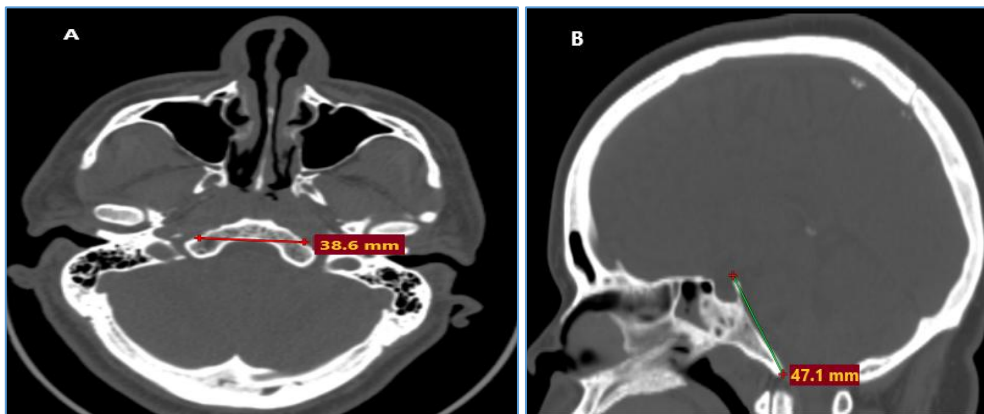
A: CT scan axial view shows the width of clivus B: sagittal view shows the length of clivus.
